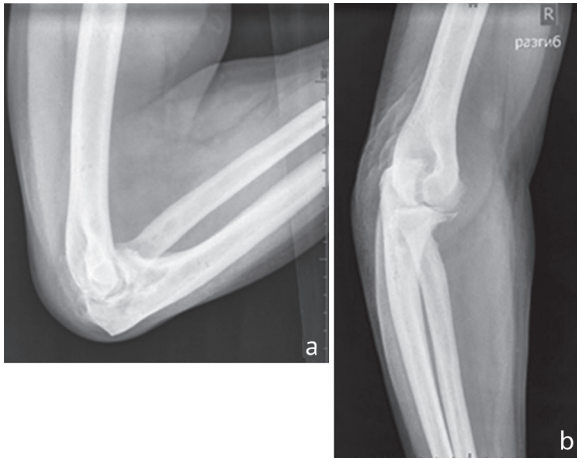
Lateral X-rays of the patient's right elbow joint with maximum flexion (a) and maximum extension (b) of the forearm one year after surgery
